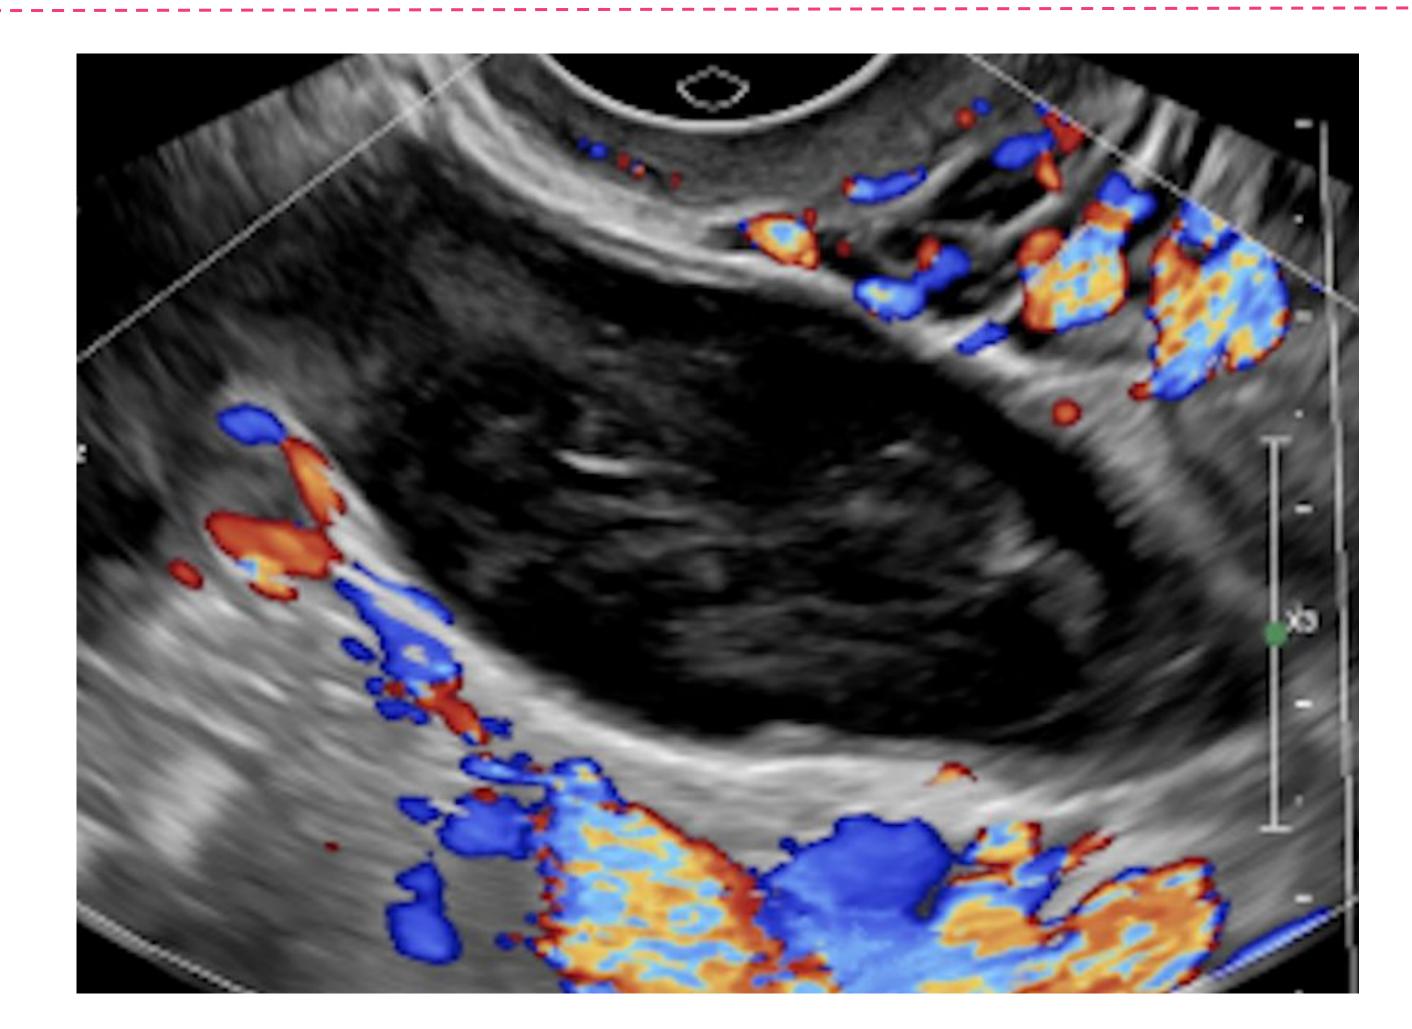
Ultrasound images taken at the time of admission.
